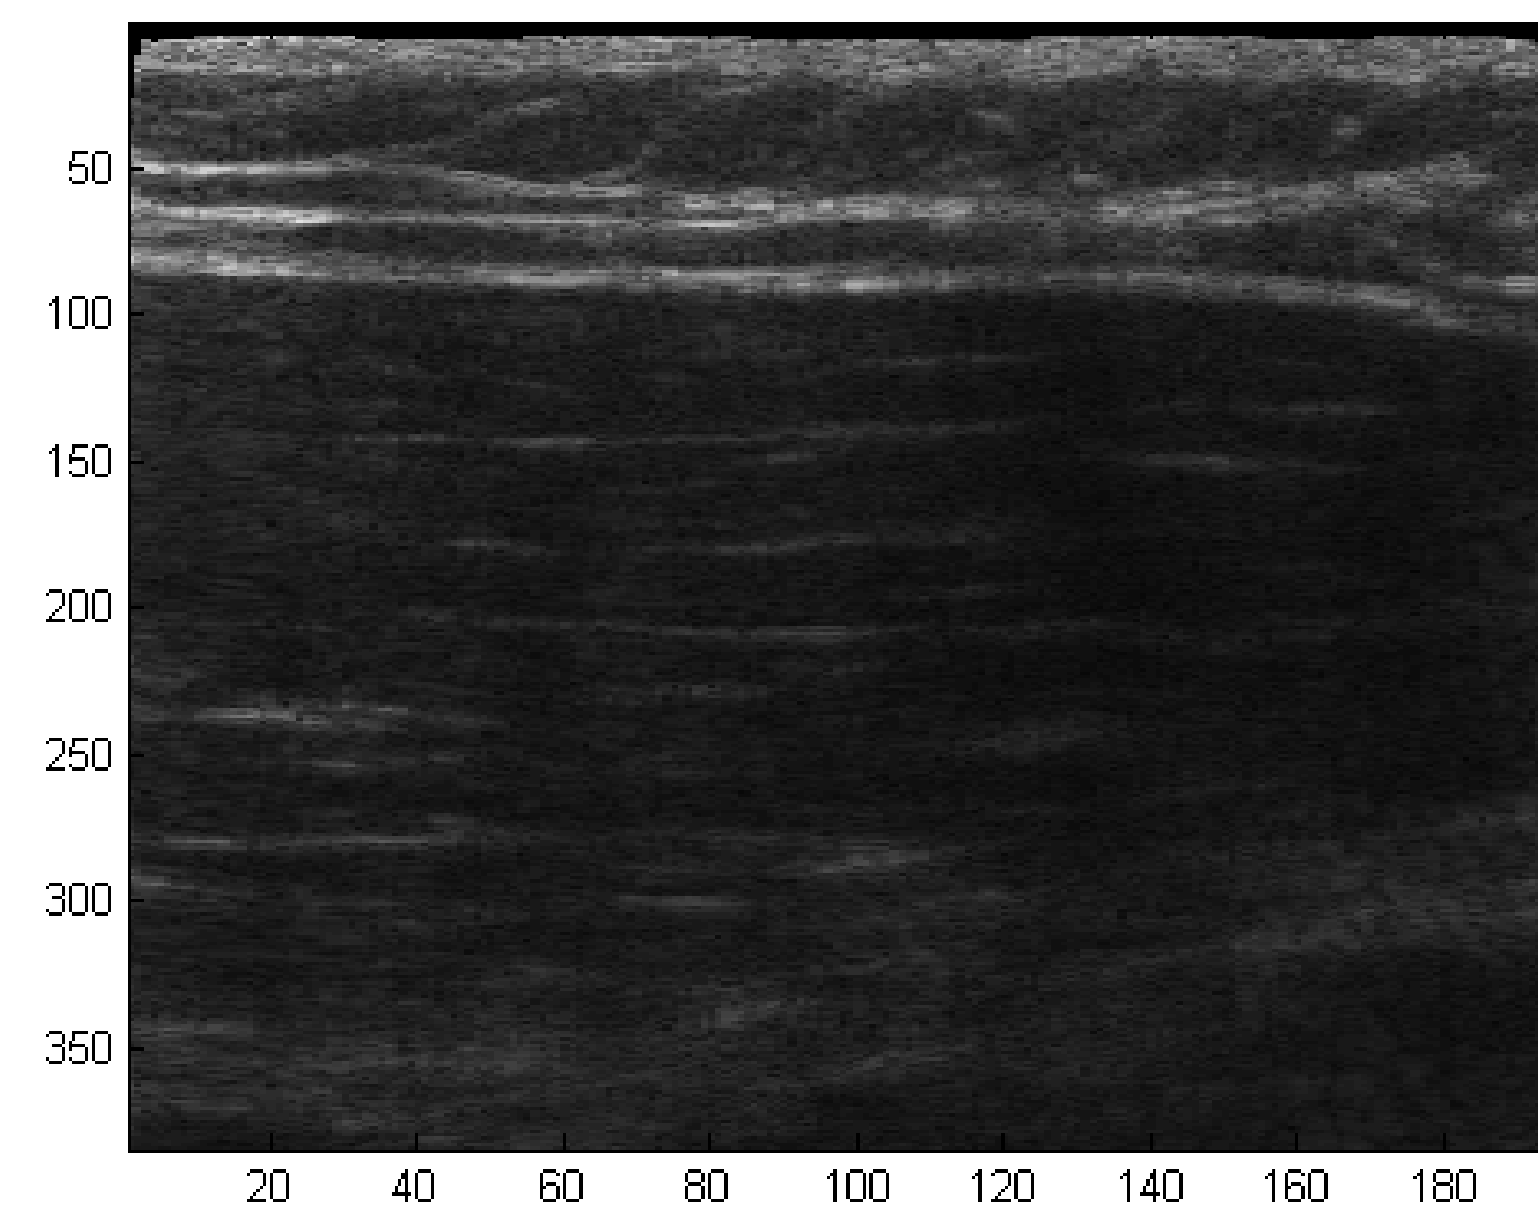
Ultrasound B-mode image obtained through ultrasound elastography data collection depicting leg muscle
